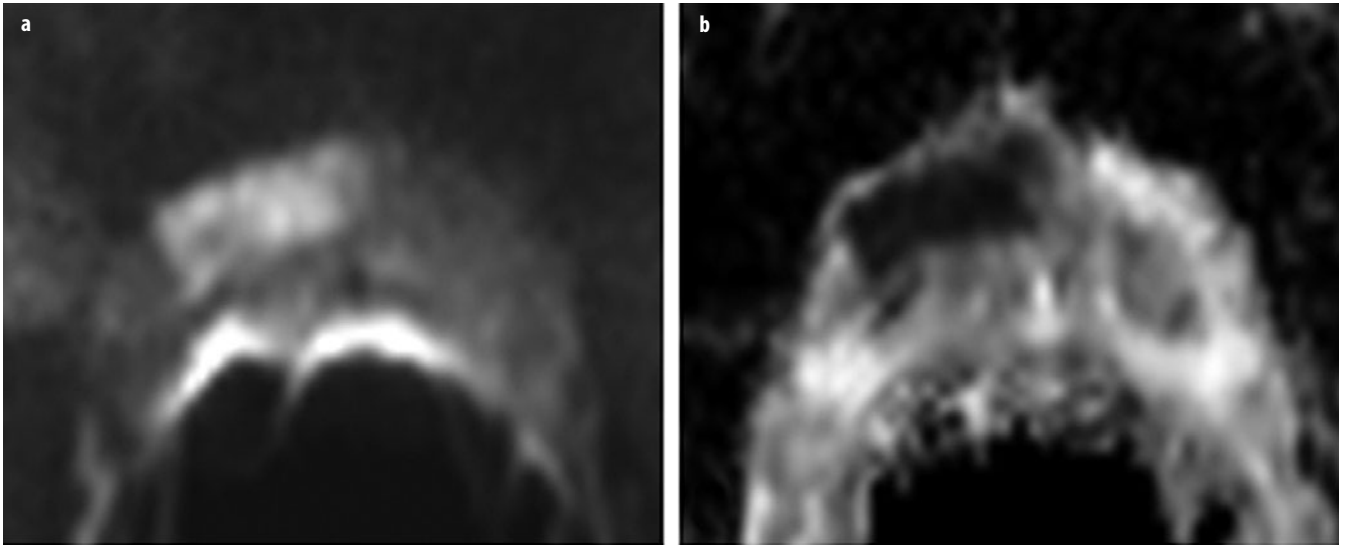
a, b. a Axial diffusion-weighted imaging (DWI) with a b-value of 1,000 shows a lesion ventral right with a hyperintense signal. b This area has low signal intensity in the corresponding apparent diffusion coefficient (ADC) map. With normal diffusion, the peripheral zone of the prostate has high signal intensity in ADC and low signal intensity in b-1,000. After prostatectomy, an acinar prostate adenocarcinoma with a Gleason score of $4 + 3 = 7$ was diagnosed ventral right
